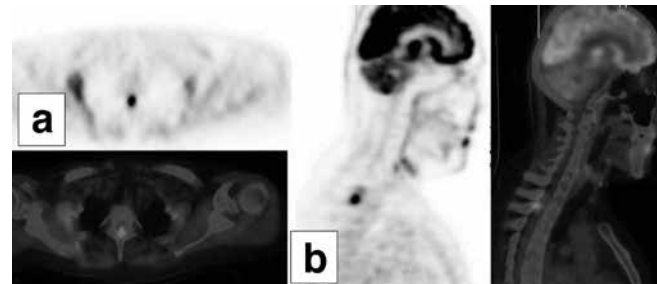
Transaxial (a) and Sagittal (b) FDG-PET and fused images showed intense FDG accumulation (the maximum standardized uptake value (SUVmax): 15.7) along the T1-2 spinal cord with no other sites of metastatic spread
